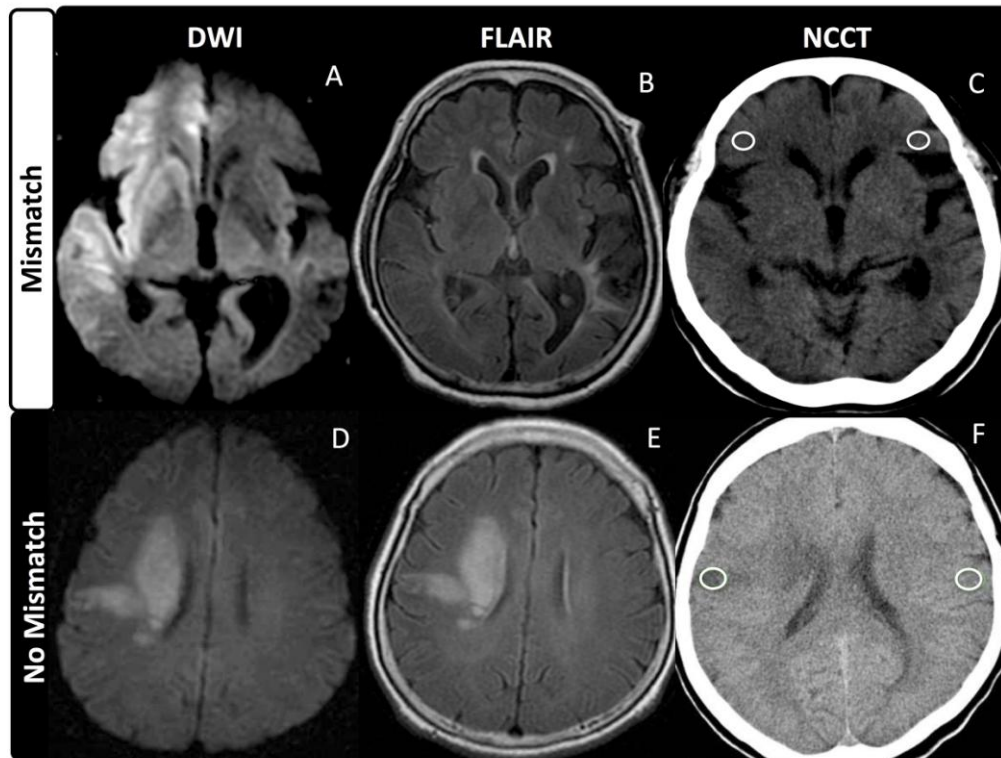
MRI DWI-FLAIR mismatch and no mismatch when compared to NCCT hypoattenuation. Panel A-C shows a patient with mismatch. Panel A shows a DWI lesion without corresponding FLAIR lesion in panel B. NCCT in panel C does not demonstrate any significant hypoattenuation in the ischemic region. rCT (ratio of ipsilateral/contralateral NCCT HU density within the circular mirror ROIs) was 1.02. Panels D-E show a DWI lesion with a corresponding FLAIR lesion. The NCCT in panel F shows severe hypoattenuation in the ischemic region. rCT (ratio of ipsilateral/contralateral NCCT HU density within the circular mirror ROIs) was 0.77.
